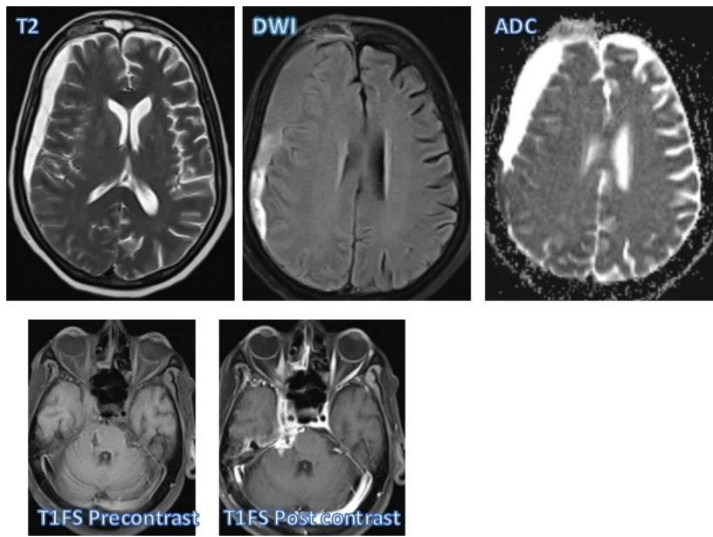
CNS involvement of ROCM T2 axial(a),DWI(b),ADC(c) showing well defined extra axial concavo convex collection with no diffusion restriction noted along right frontoparietalconvexity.T1FSprecontrast(d)andpostcontrast(e)showinginvolvementof right trigeminal nerve,cavernous sinus and orbital apex.
